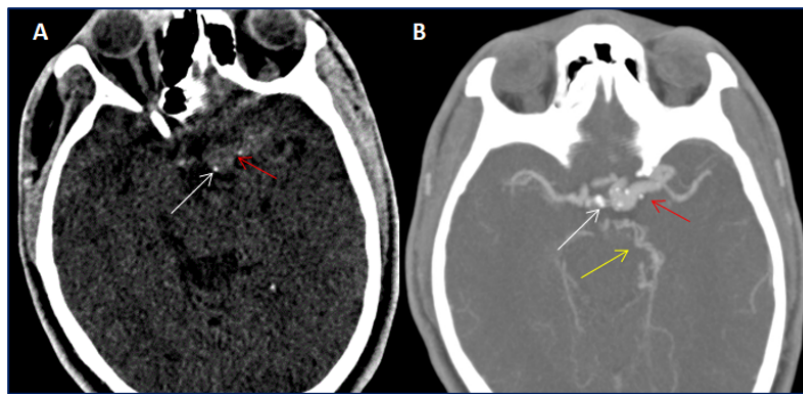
(A) Axial CT sections shows a spontaneously hyperdense appearance of the internal carotid artery and the proximal portion of the middle cerebral artery (Red arrow) containing small calcifications (White arrow), revealing after contrast injection. (B) an enlargement and twisted appearance of these arteries (Red arrow) as well as of the homolateral posterior cerebral circulation (Yellow arrow).
